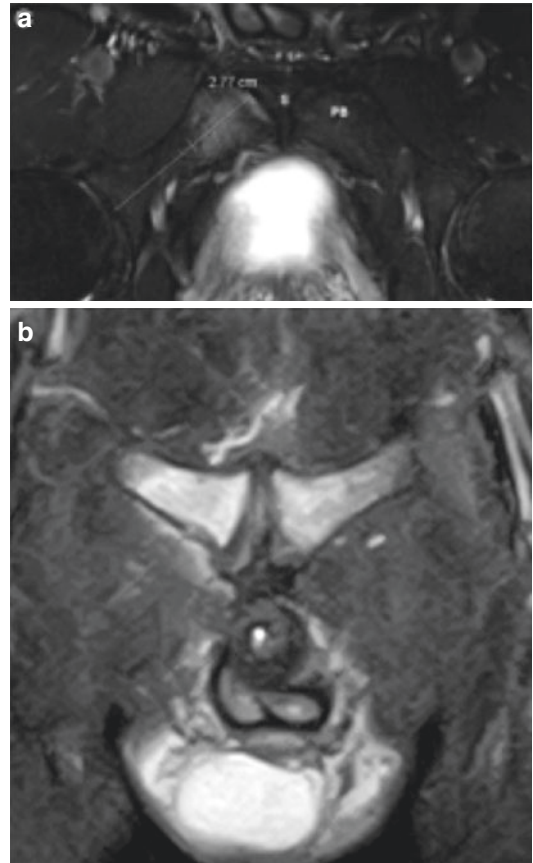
(a) MRI axial STIR and (b) MRI coronal STIR. The *first image* shows right monolateral grade 3 BME, extending from the anterior to the posterior edge of pubic bone. The *second image* demonstrates bilateral grade 3 BME
